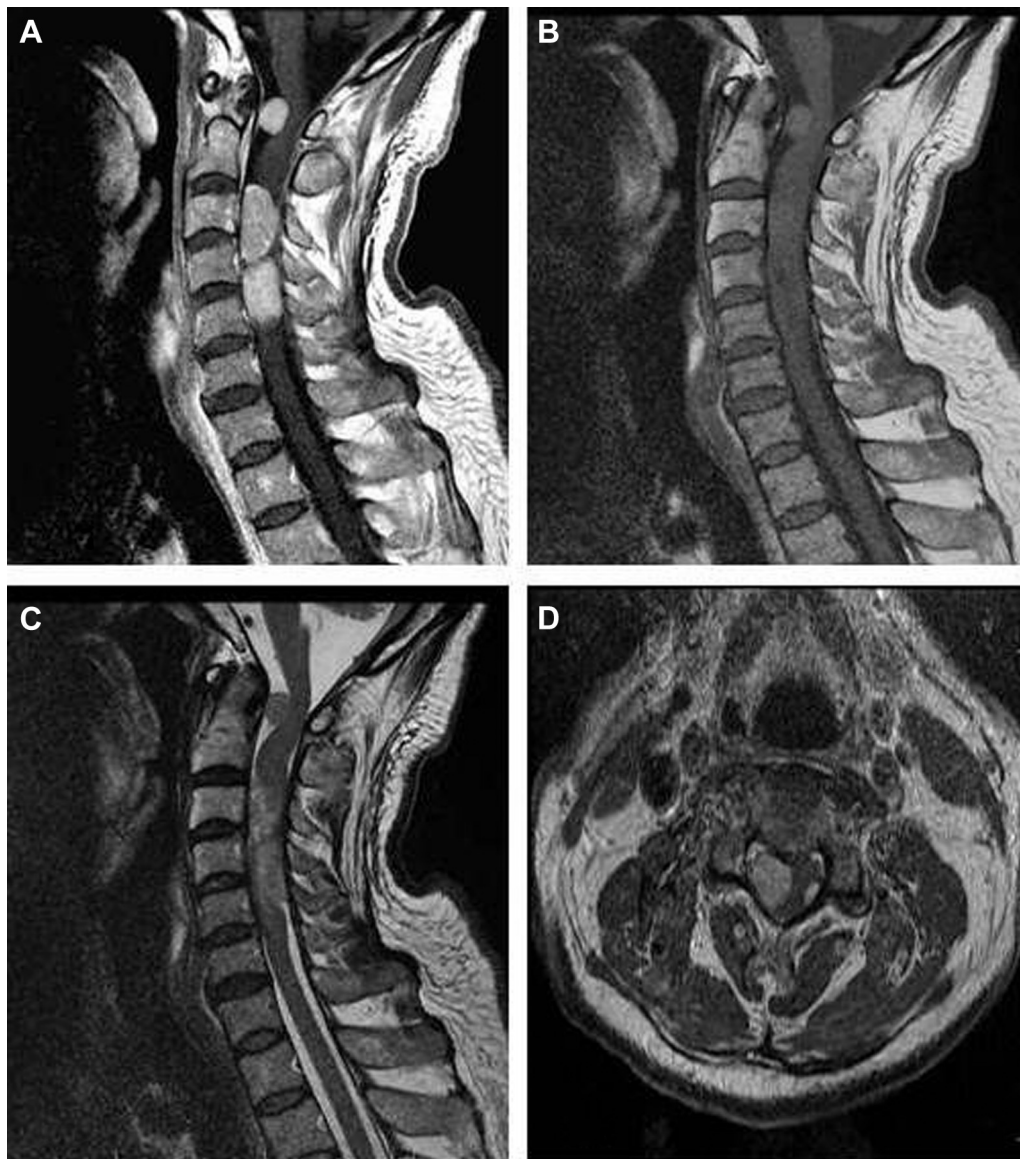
On magnetic resonance imaging examination, several ovoid-shaped solid mass lesions pressing and displacing the spinal cord, the biggest being 23×12 mm in size, at C2–C5 level were observed on contrast T1-weighted image (A). The lesions were hypointense on T1-weighted image (B), slightly hyperintense on T2-weighted image (C), and strongly enhancing on postcontrast series on sagittal and axial T1-weighted images (A and D).
